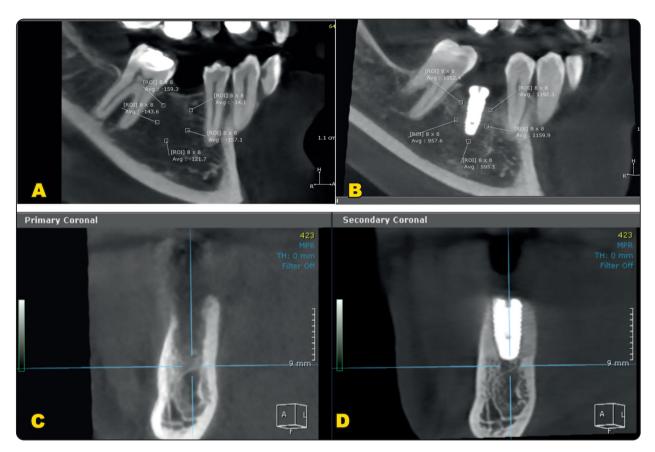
Shows radiographical analysis A) preoperative density measures in HU. B) 4 months postoperative density measurement in HU. C) shows preoperative with buccal surface defect. D) shows 4 months postoperative changes in buccal surface.
